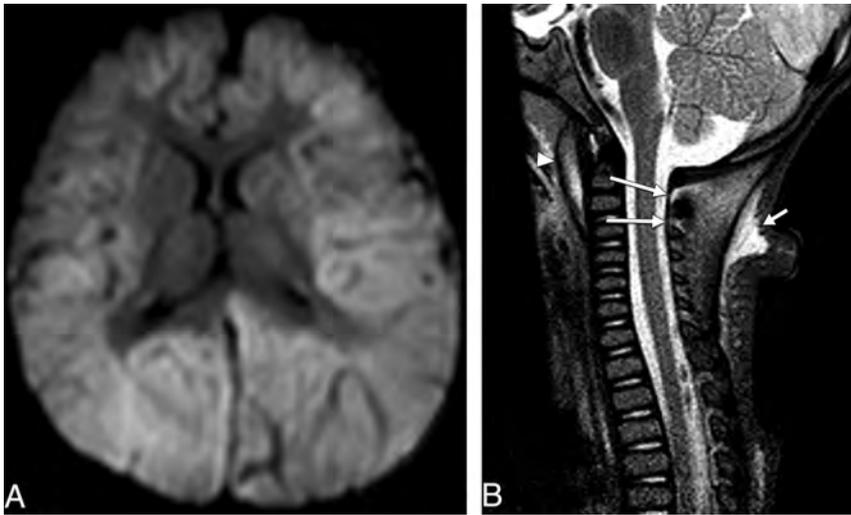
Seven-month-old patient. *A*, Axial DWI shows diffuse cerebral restricted diffusion, worse on the left. There is mild midline shift, left to right, caused by a left hemispheric convexity subdural hemorrhage (not shown). *B*, Sagittal midline STIR image demonstrates interspinous (long arrows) and nuchal ligament injury (short arrow). There is also prevertebral edema (arrowhead).
